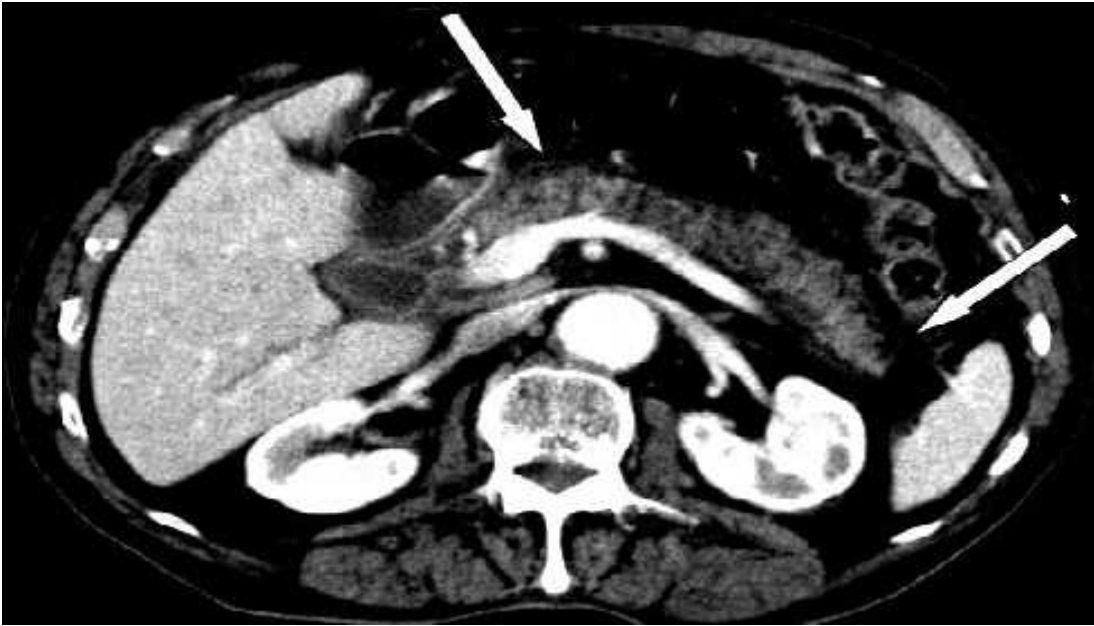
CT image interstitial oedematous pancreatitis with peripancreatic fat stranding (arrows)
